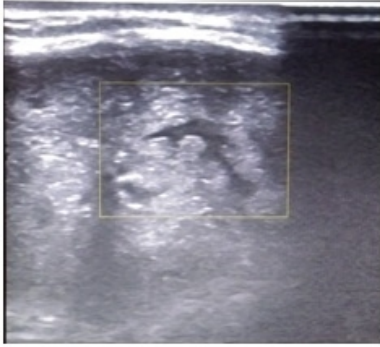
Breast ultrasound shows inhomogeneous, solid-appearing mass containing multiple cleft like cystic spaces.
